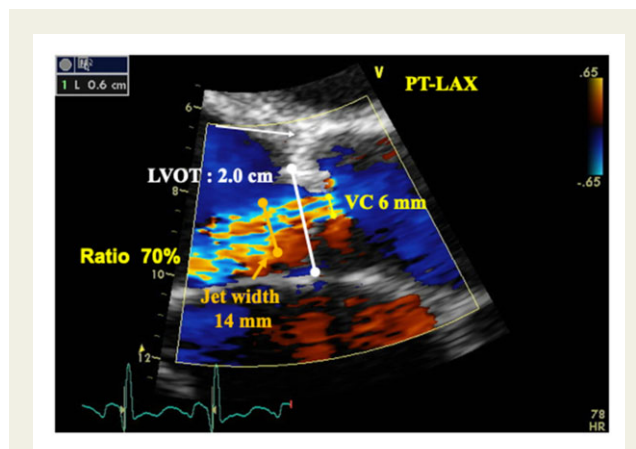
Colour Doppler assessment of the jet width ratio (maximum colour jet diameter divided by LV outflow tract diameter) in a patient with severe AR. VC, vena contracta.
